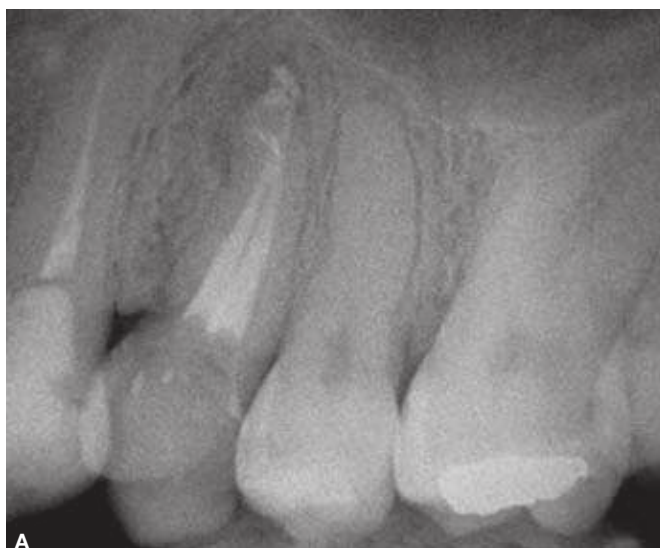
A) Pre-operative radiograph. A fractured endodontic instrument can be noticed. The patient was experiencing pain and discomfort after root canal sealing. B) Six month review radiograph. It can be noticed the MTA apical plug in surgical canal path. Satisfactory healing can be appreciated.
